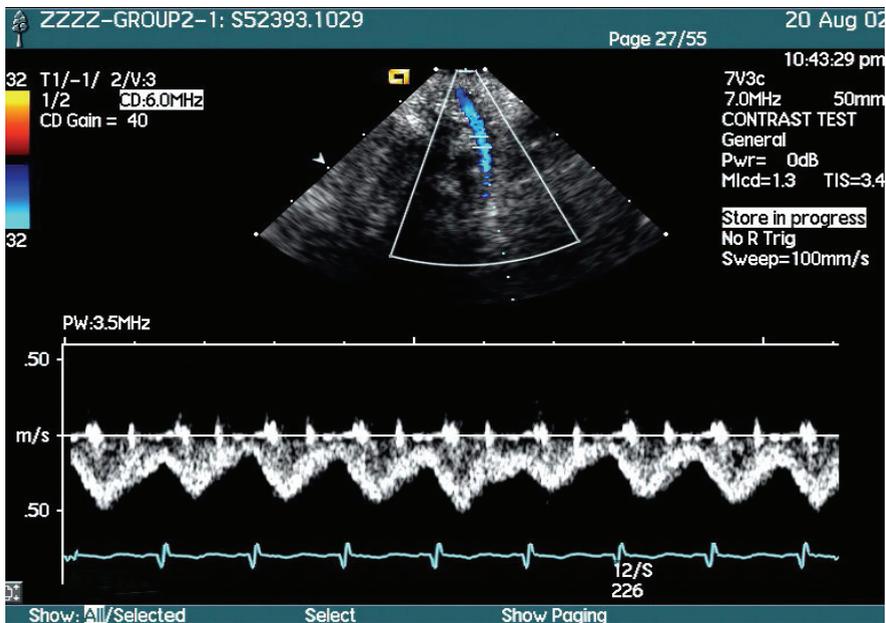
Normal SVC Doppler flow
